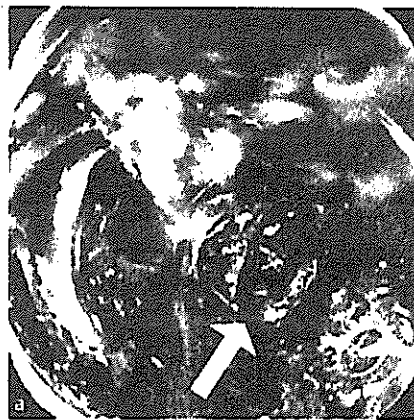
Endoscopic view of the mid-esophagus, showing a perforation (arrow) seen during submucosal dissection (a), and the view after closure of the perforation by endoclips (b). The chest radiograph showed pneumomediastinum and subcutaneous emphysema (c).
